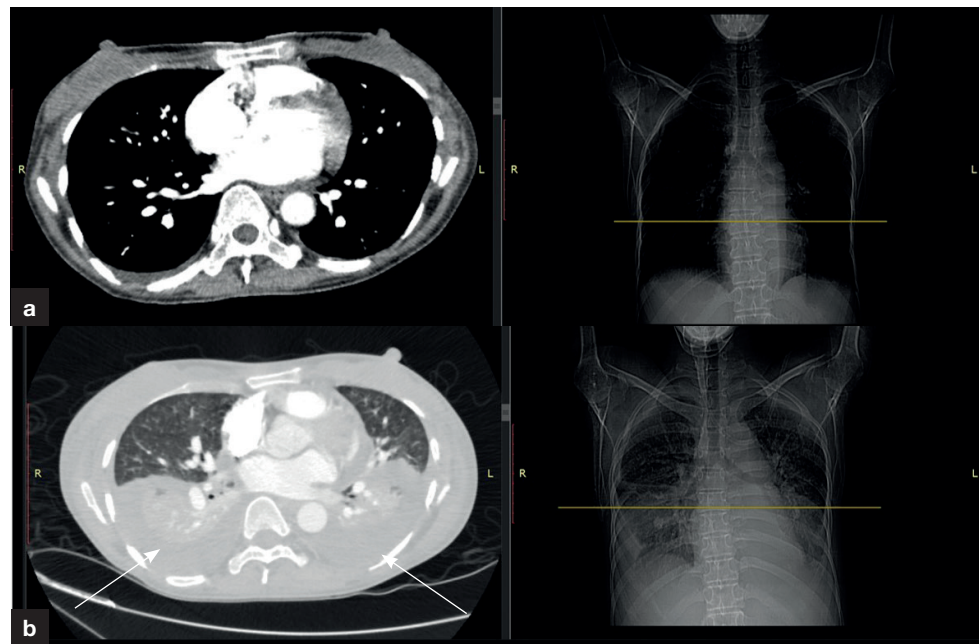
a. Computed tomography pulmonary angiogram taken just before starting treatment for tuberculosis. b. Large pleural effusion (arrows) on a computed tomography pulmonary angiogram taken 7 days later.
